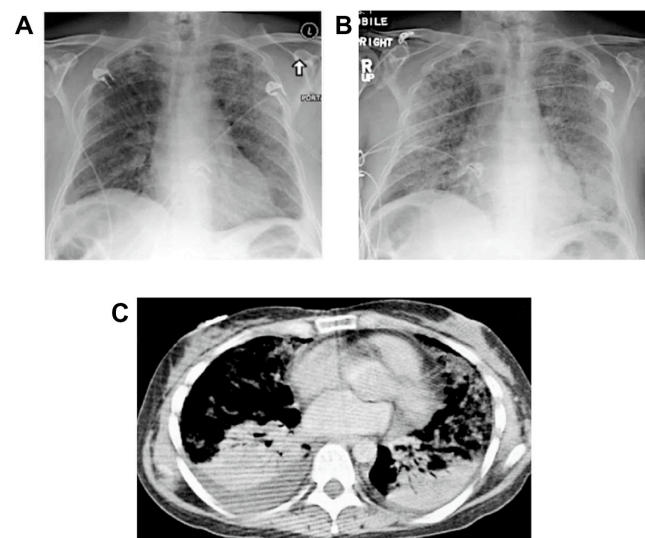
Early ALI/ARDS showing mild interstitial pulmonary edema (Figure 3a), progressing over several hours despite diuretic therapy (Figure 3b). Computed tomography of established ALI/ARDS showing dependent (dorsal) congestive atelectasis and relative sparing in non-dependent anterior zones.
